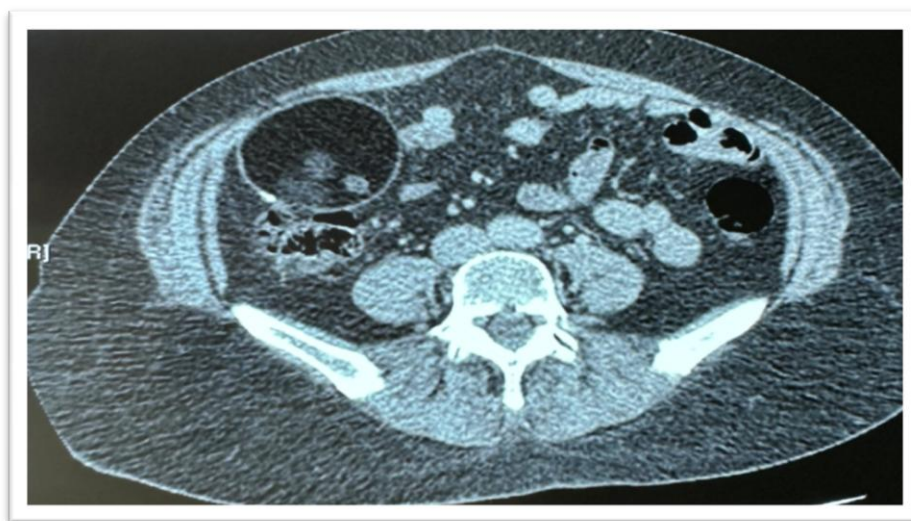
Abdominal CT scan showed a thin-walled mesenteric cystic lesion (with a few calcifications), with highly hypodense content (measured fatty density of 170 HU) and an intracystic, hypo-dense, sloping formation measuring 72mm x 71mm in the infrahepatic region
